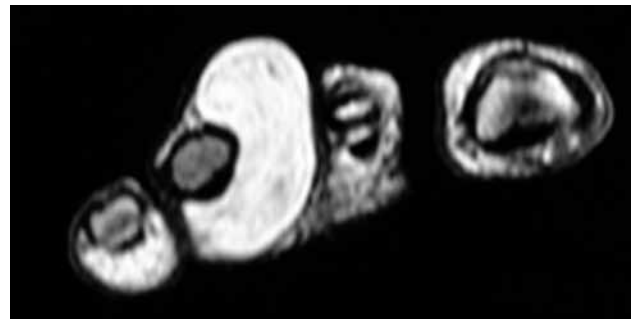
T1-weight coronal magnetic resonance imaging showing a well-defined lobulated mass surrounding the second web space, consistent with lipomatous tumor.
